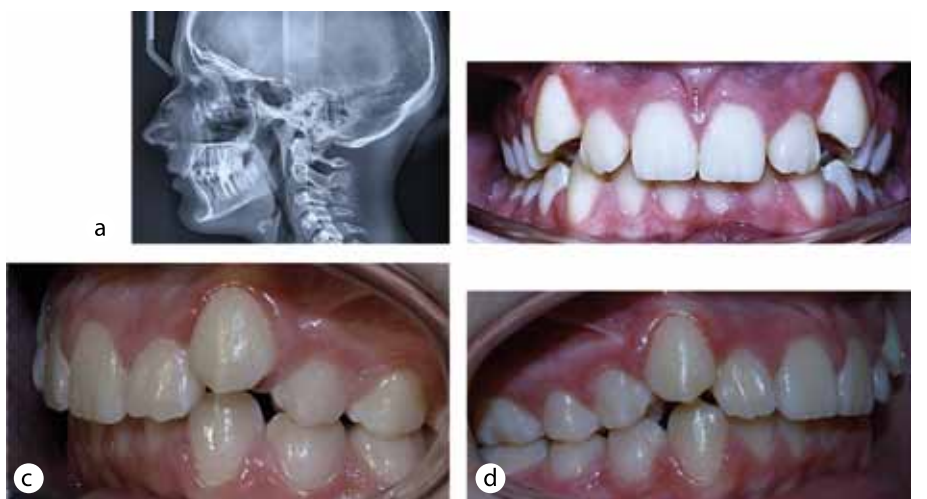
X-ray and photographic features of dental system, patient S., 14 y.o., with mild CTD. Head telorentgenogram, lateral projection (a), pathological occlusion (b — direct projection, c — left-side lateral projection, d — right-side lateral projection).
